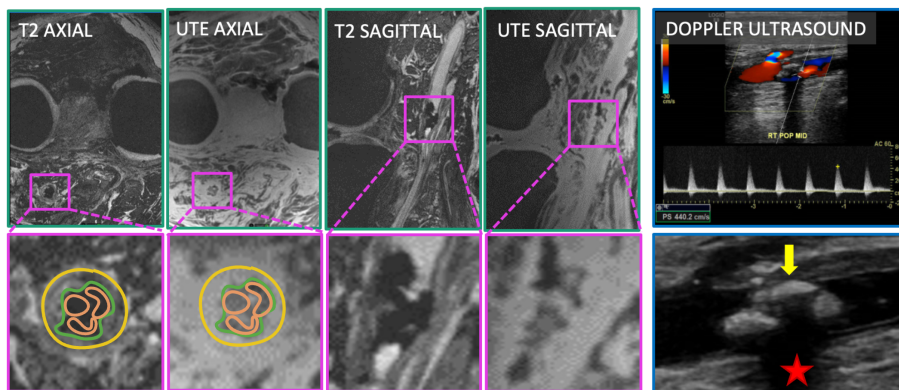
7T magnetic resonance imaging and Doppler ultrasound of a popliteal artery plaque. On ultrasound images (right) an echogenic, nodular, calcified plaque (yellow arrow) with shadowing (red asterisk) causes significant hemodynamic stenosis (peak systolic velocity 440 m/s); detailed plaque morphology can be determined only to a very limited extent. 7T T2 and ultrashort echo time (UTE) images show explicit plaque structure with speckled calcium (orange outline, hypointense) in an isointense dense collagen matrix (green outline). Vessel lumen is outlined in yellow.
